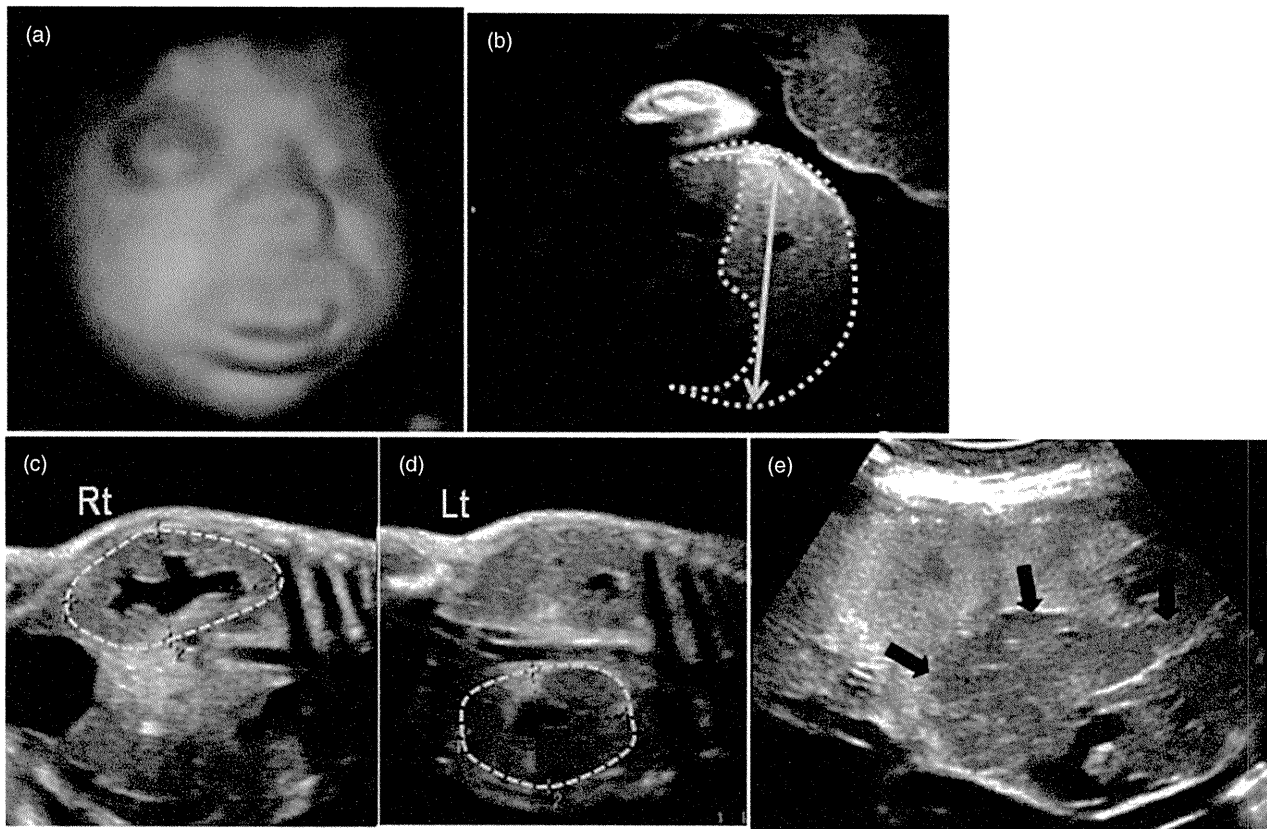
(a–e) Fetal and placental findings. Characteristic findings were seen using ultrasonography. (a) Macroglossia. (b) Hepatomegaly, measuring 87 mm (normal range at 29 weeks: 39 mm). (c,d) Enlarged kidneys, measuring 60 × 32 mm in right side, and 50 × 37 mm in the left side (normal range at 29 weeks: 28 × 15 mm). (e) A large, well-circumscribed tumor (12 cm in diameter) was found on fetal side of the placenta (arrows).
